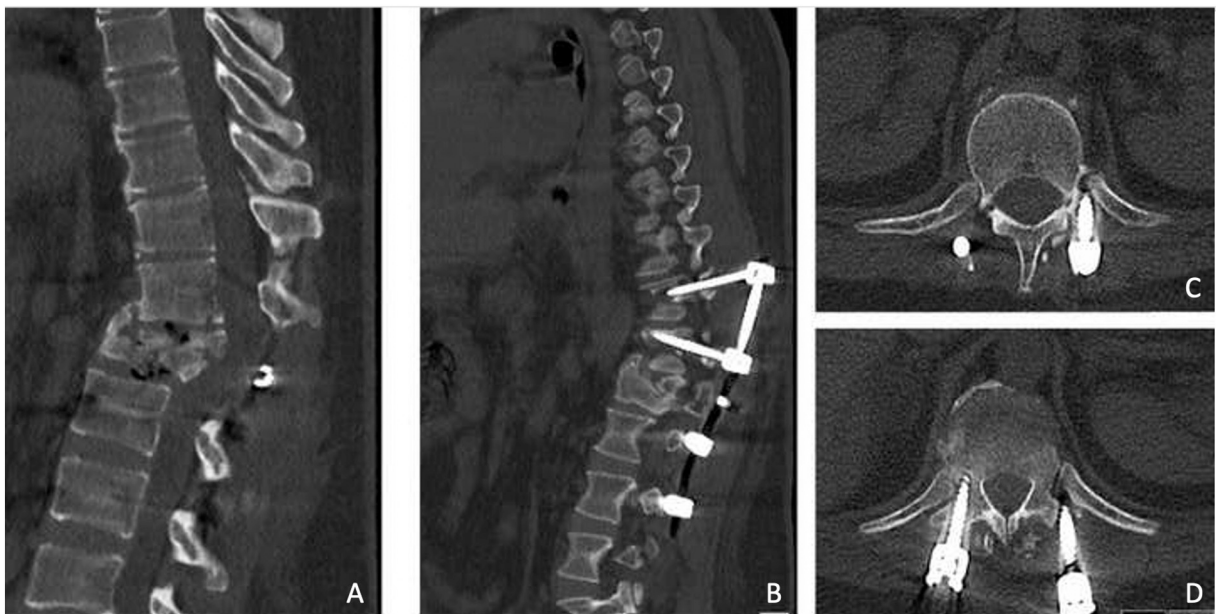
Thoracolumbar CT scan of the patient 5 months after the initial surgery. 2A. Sagittal view showing kyphosis in thoracolumbar junction. 2B. Sagittal view with misalignment of screws in left T11 and T12 vertebrae. 2C and 2D. Axial views of T11 and T12 vertebra with pulled out screws in left side, respectively.
